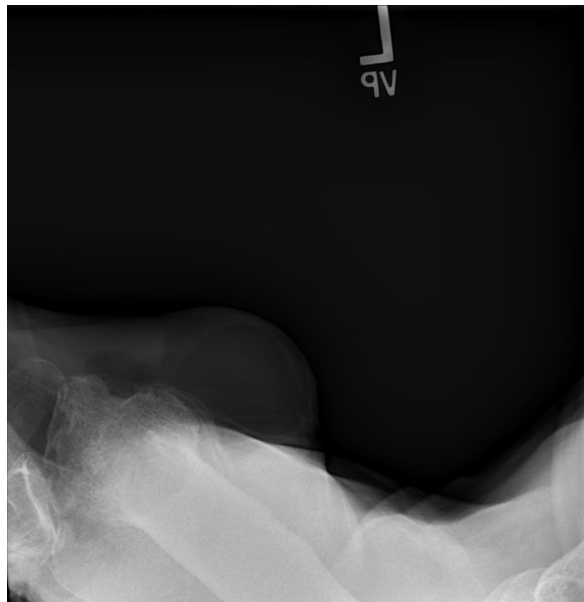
AP and Axillary Shoulder X-Rays of Proximal Humerus Fracture Dislocation. AP and axillary X-rays of the right and left shoulders in a skeletally mature individual. They reveal the presence of bilateral proximal humerus fractures and bilateral posterior dislocations of the humeral heads.
